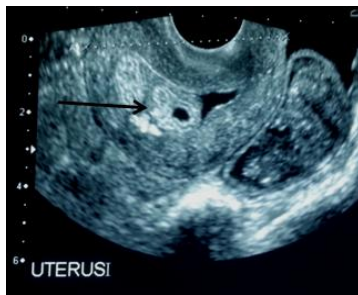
Longitudinal ultrasound scan showing tubular fluid-filled structure within the uterus (→).
